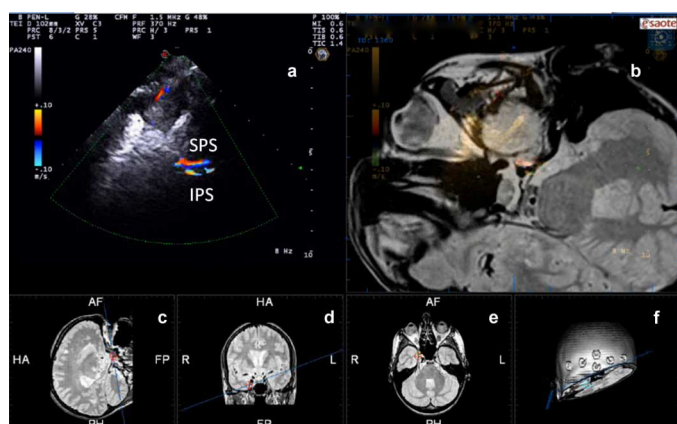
Example of Superior Petrosal Sinus (SPS) and Inferior Petrosal Sinus (IPS) insonation. (a) US fused with MRI; (b) MRI oblique plane; the vessel position is confirmed by the marker visualized on sagittal (c), coronal (d) and axial (e) views; (f) cut MRI rendering corresponding to the current US insonation plane.
